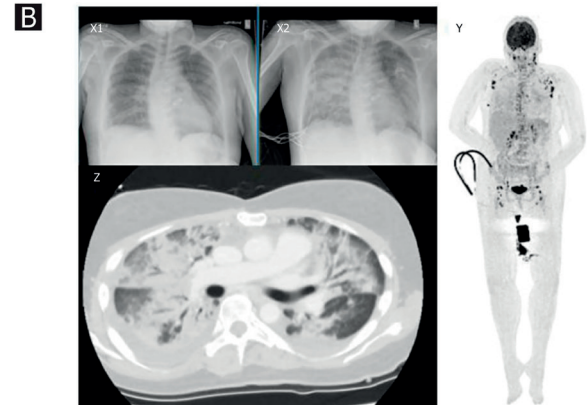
Radiological and nuclear imaging studies. X: Chest X-ray at admission (1) and at the time of intubation showing bilateral diffuse consolidations. (2). Y: PET-CT of multiple enlarged lymph nodes suggesting widespread adenopathy. Z: CT thorax at intubation showing bilateral dense consolidations merging in peripheral groundglass opacifications suggestive of (early) ARDS.
